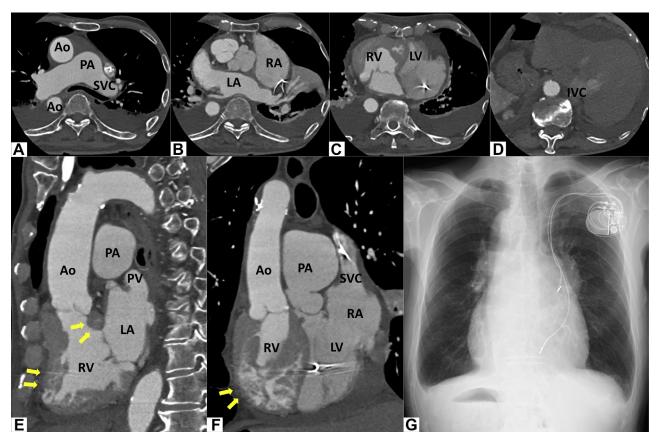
(A-F) Chest computed tomography images. The aorta arose from the anatomic right ventricle with the moderator band and the subaortic infundibulum (arrows). The anatomic right ventricle was connected to the left atrium. The right atrium, which was connected to the superior and inferior vena cava, was located on the left side with the presence of situs inversus. (G) A chest radiograph image after transvenous permanent pacemaker implantation. Ao, aorta; IVC, inferior vena cava; LA, left atrium; LV, anatomic left ventricle; PA, pulmonary artery; PV, pulmonary vein; RA, right atrium; RV, anatomic right ventricle; SVC, superior vena cava,.
